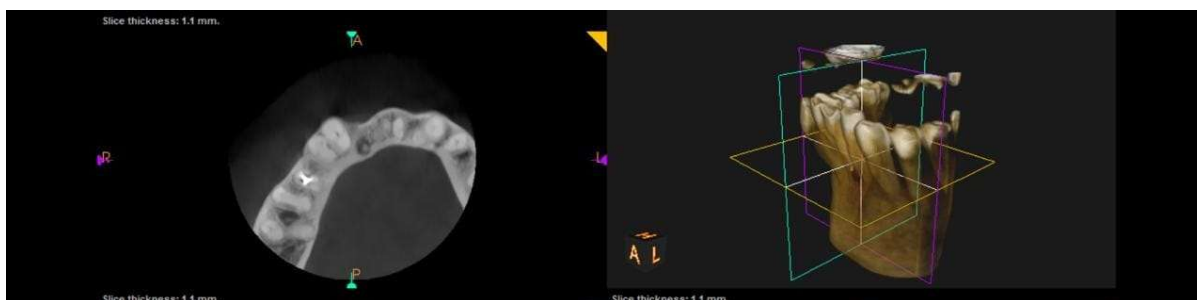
CBCT Image showing obturation done using obtura ii system.
